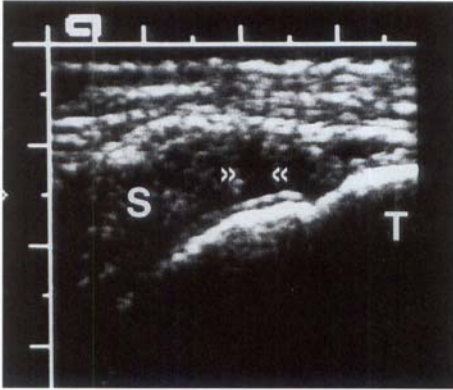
Case 6. Small full thickness rotator cuff tear. Longitudinal sonogram showing area of discontinuity (> <) in the supraspinatus tendon(s) near its point of insertion on the greater tuberosity (T).
